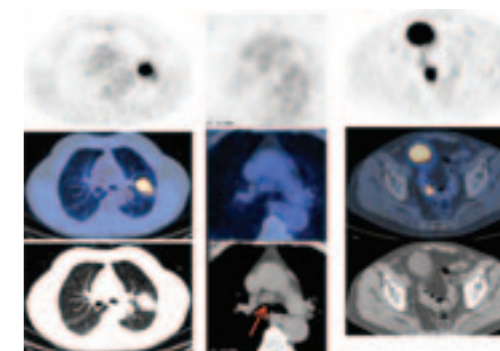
Patient with right-sided bronchial carcinoma. An enlarged lymph node seen on CT (all CT images in bottom row) is unequivocally defined as benign on the PET scan (all PET scans in top row), as there is no FDG uptake. Fused PET-CT images are shown in the middle row. In addition, there is an FDG-containing focus which is localised into the large bowel on CT. The latter lesion was found to be a villous adenoma. In an extended review of over 3000 PET-CT scans we found that in 3% of all patients referred for tumor imaging, a second malignancy or pre-malignancy was present in the large bowel.
